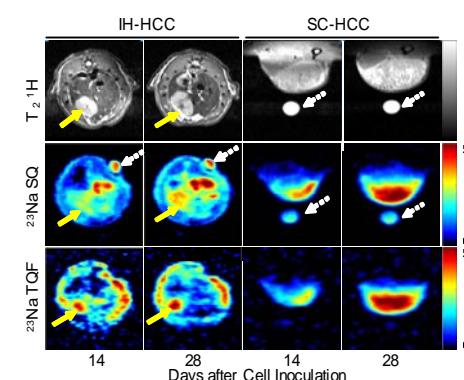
DWI  $^1\text{H}$ , SQ and TQF  $^{23}\text{Na}$  MRIs of IH and SC HCCs 14 and 28 days after N1S1 cell inoculation. IH-HCCs are marked by yellow arrows and the references are marked by the dotted white arrows.
